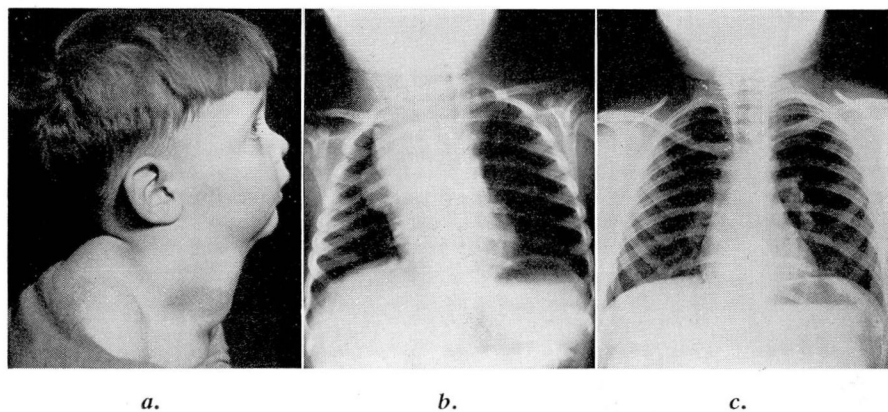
a. Photograph showing right side of neck. b. Roentgenogram of chest showing involvement of mediastinum. c. Roentgenogram of chest five years after implantation of radon seeds seen in right neck and upper mediastinum.
